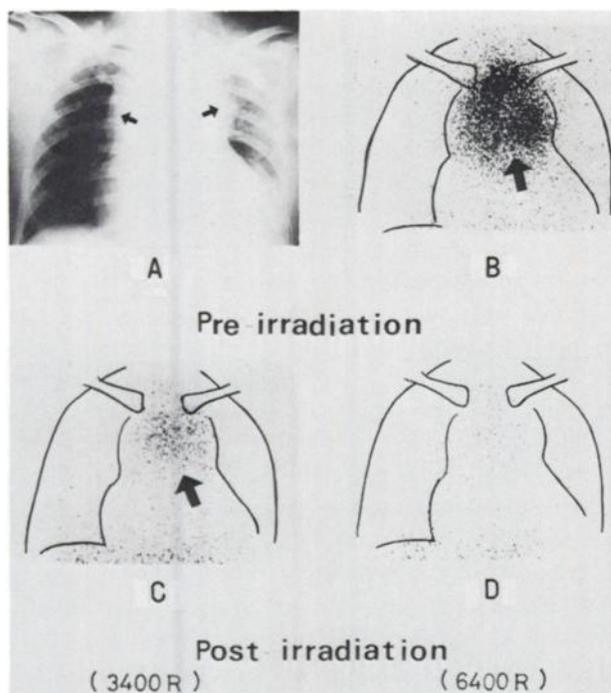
Case 3. Malignant thymoma. Chest x-ray (A) shows widened mediastinum. Gallium-67 scintigram (B) reveals hot area corresponding to shadow on chest x-ray. Gallium-67 scintigrams (C and D) were taken during and after ^{60}Co radiotherapy. Uptake of ^{67}Ga -citrate decreased in proportion to radiation dose.
